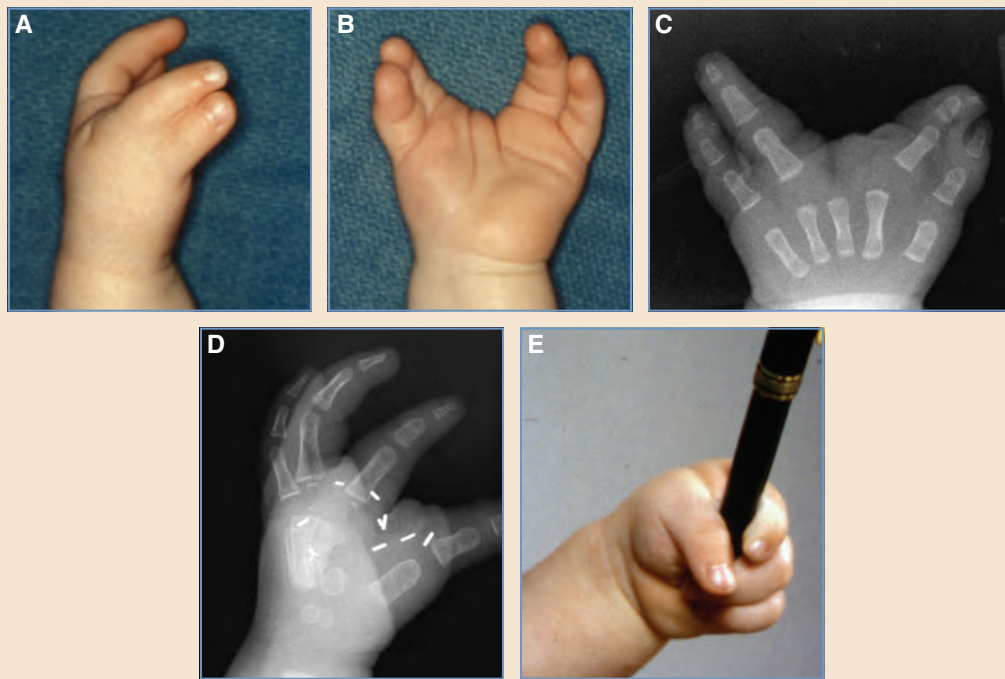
A, This 1-year-old patient had a cleft hand with absence of the middle finger and thumb-index syndactyly. B, A gross grasp was present in the central cleft. The tight, incomplete simple syndactyly between the thumb and index finger produced significant radial clinodactyly of the index finger. C, A preoperative radiograph showed very tight skeletal alignment of the first and second rays. The middle finger metacarpal was unsatisfied, and a wide, central soft tissue cleft was present. D, This oblique postoperative radiograph shows that the newly created first web space is wide, and that the second metacarpal is now unsatisfied, because the index finger was moved onto the stump of the middle metacarpal. E, The patient is able to grasp small and larger objects. Further correction of the radial clinodactyly of the index finger may be required when the patient is older.
